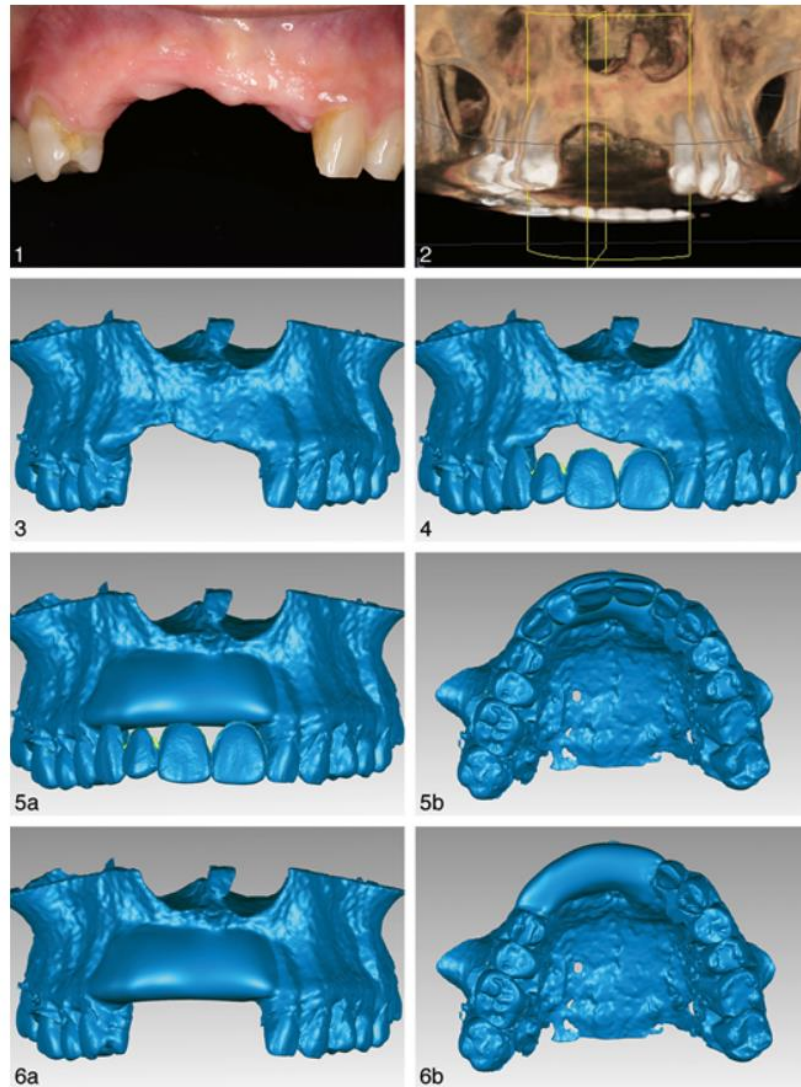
Projections of Advanced CBCT and CAD/CAM Tools of a Maxilla. This figure depicts screenshots and images from the clinical report made by Al-Ardah et al. (2018). (1) A picture of the patient's alveolar defect. (2) a CBCT scan of the defected area integrated into a measuring software. (3 – 6b) virtually designed 3D-imaging projecting the damaged area first, ending with designing the planned 3D virtual ridge augmentation (Figure taken from Al-Ardah et al., 2018).
